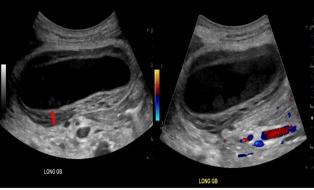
Grayscale and color Doppler ultrasound images of diffuse gallbladder wall thickening (double head arrow) with heterogeneous low echogenicity areas of edema within the thickened wall.
